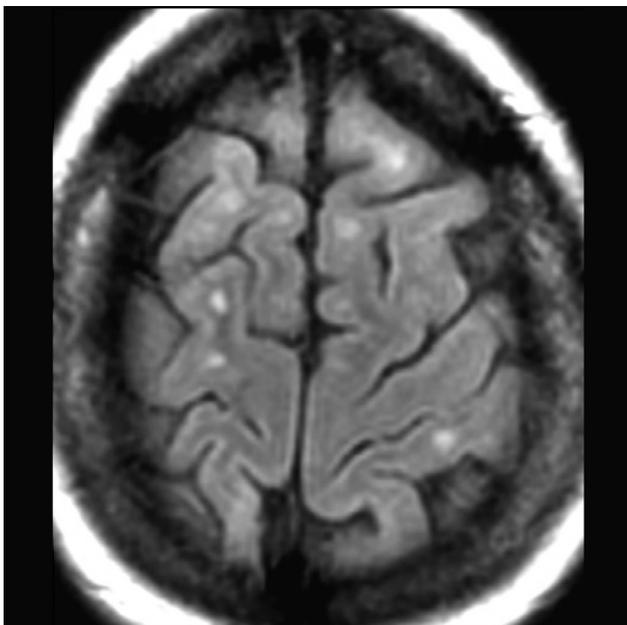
Axial FLAIR sequence. Juxtacortical WMH are highly suggestive of MS
